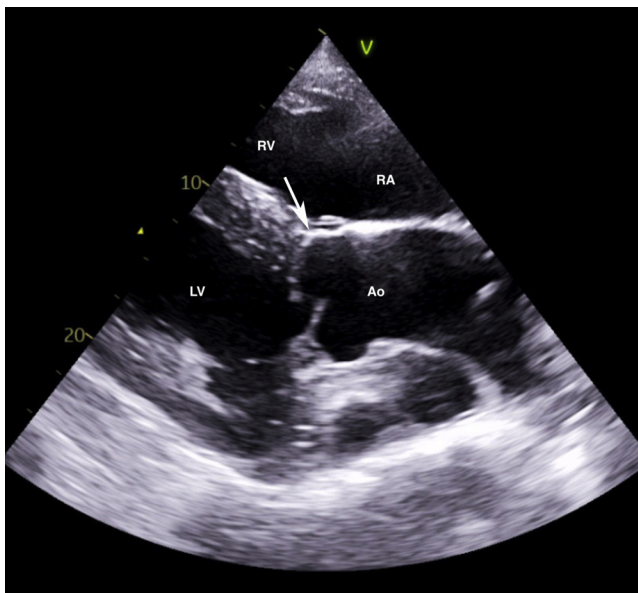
Two-dimensional echocardiogram of the left ventricular outflow tract view obtained from a right parasternal window, similar to Figure 1, performed 2 weeks after discharge from the hospital with identical findings on day 634 post discharge. The right ventricular inlet is displayed in the near field. Notice that the previously detected ACF (arrow) is no longer visible. Ao, Aorta; LV, left ventricle; RA, right atrium; RV, right ventricle.
